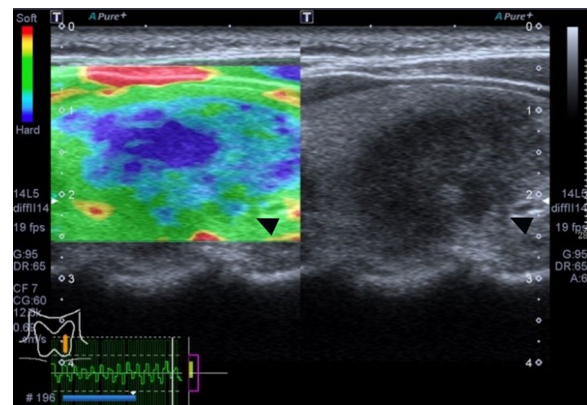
Thyroid nodule showed ES of 3. A 50-years-old female came to hospital for a physical exam. Ultrasound image showed the nodule of subacute thyroiditis exhibited half in blue and half in green was scored as 3 (marked with a black triangle). ES=elasticity score
